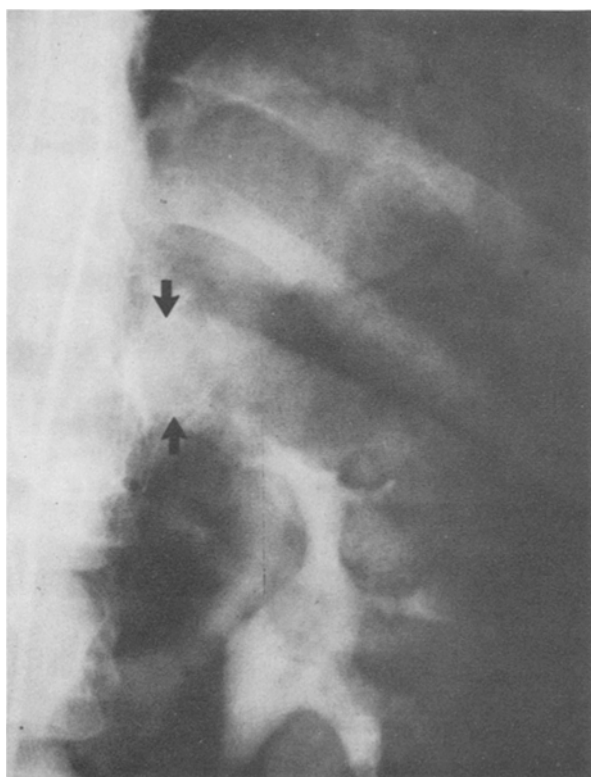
CT scanning and this arteriogram demonstrated a left adrenal mass in a hypertensive patient; this localization information preceded diagnostic confirmation of the suspected pheochromocytoma, and adrenalectomy revealed a nonfunctioning cortical adenoma with no postoperative change in the patient.
